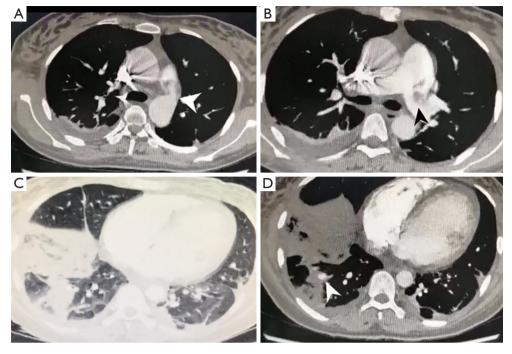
PDA combined with infective endocarditis and PAA. (A,B) CTPA images show PDA (arrowhead) and dilation of the main and left trunk of the pulmonary artery with bacterial thrombi formation (black arrowhead). (C,D) Lung and mediastinal window shows multiple inflammatory lesions of both lungs, and small nodules with obvious enhancement (arrowhead) can be seen in the inflammatory lesions of the right lower lobe on enhanced examination. PDA, patent ductus arteriosus; PAA, pulmonary artery aneurysm; CTPA, computed tomography pulmonary angiography.
